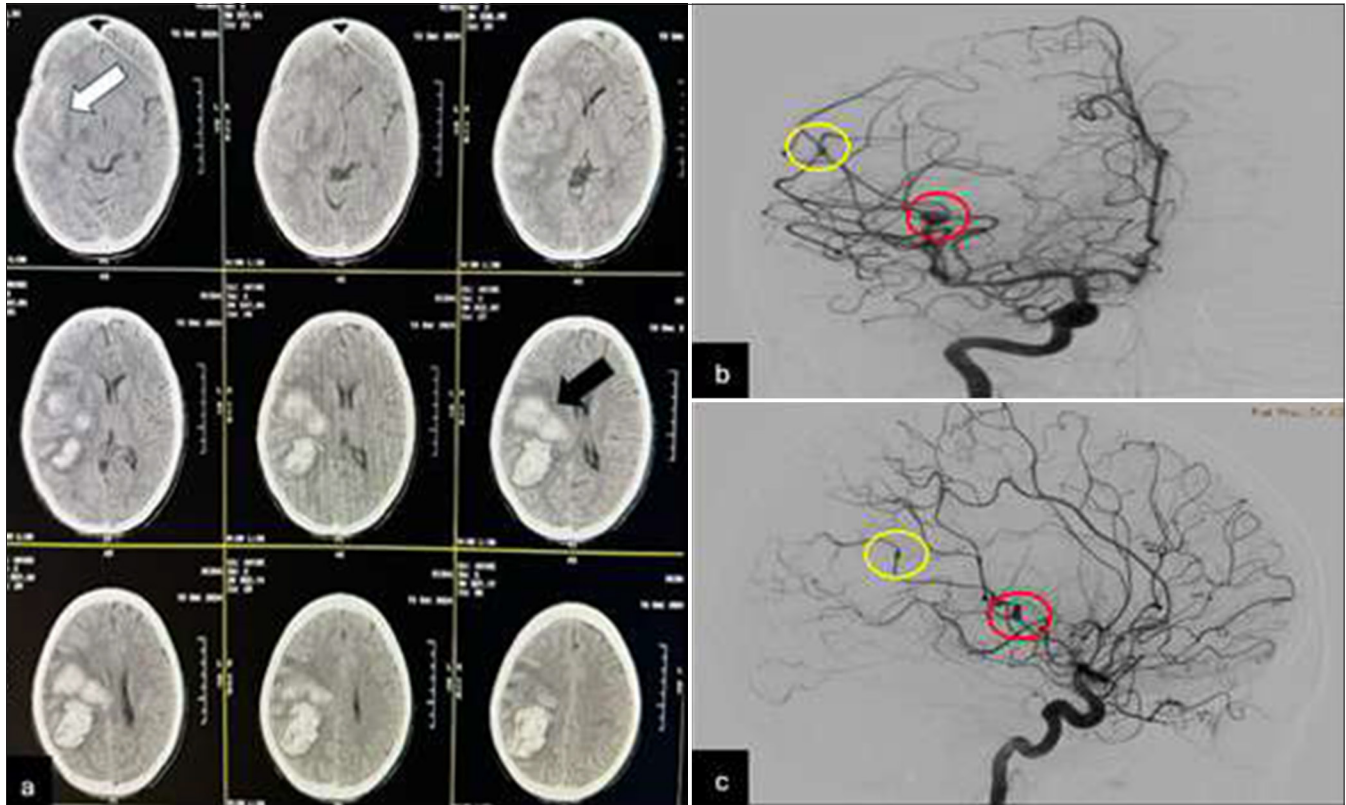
(a) Head non-contrast computed tomography scan showed subarachnoid hemorrhage in the right parietotemporal lobe (white arrow) and intracerebral hemorrhage in the right parietal lobe with volume estimation ± 57 cc (black arrow). (b and c) Digital subtraction angiography showed ruptured cerebral mycotic aneurysms on distal right MCA, postero-parietal branch (M3) (red circles) and angular branch (M4) (yellow circles).
